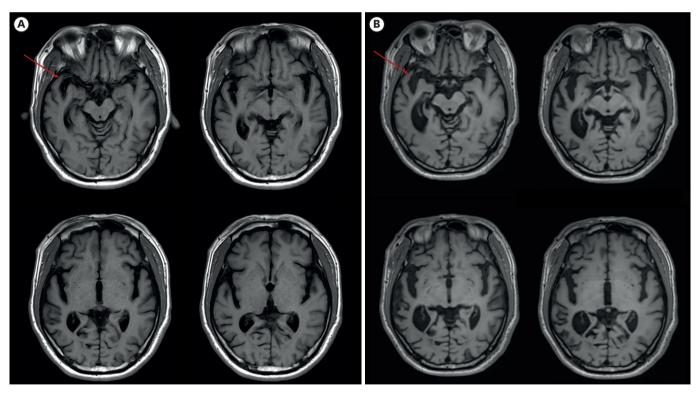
(A, B) Brain MRI of the patient. Compared to the previous study (A), transaxial MRI after 3 years show atrophic changes in right frontal and temporal cortices around the sylvian fissure (red arrow, B). (C) Transaxial amyloid PET images show asymmetrical amyloid deposition patterns. A greater amyloid deposition is observed in the left frontal cortex (dashed arrows). (D) Transaxial TeF-fluorodeoxyglucose PET images exhibit a decrease in metabolism in the right fronto-parieto-temporal occipital lobe, right caudate nucleus, right basal ganglia, left parietal, and bilateral posterior cingulate gyrus (more severe in the right side). (E) Results of SNSB performed at the patient's initial visit. (F) Results of SNSB performed at 1-year follow-up.
